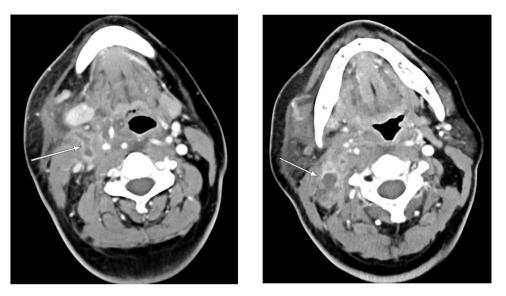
a and b. Axial views of CT neck with and without IV contrast. a) White arrow showing extension of right internal jugular vein thrombus into the retromandibular vein. b) White arrow showing a right sided supparative lymph node, measuring 2 cm, surrounded by extensive fluid in the retropharyngeal and parapharyngeal space and inflammatory stranding.
